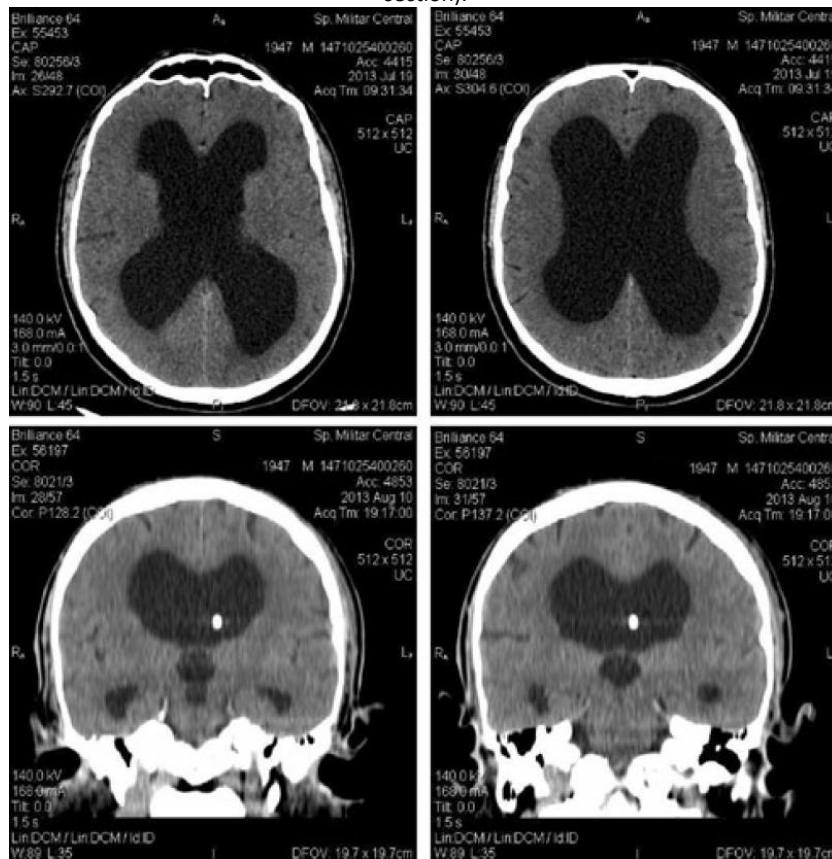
Preoperative MRI (T2 sequence) and postoperative CT scan; right ventricular catheter; prominent convexity sulci; incipient cortical atrophy
